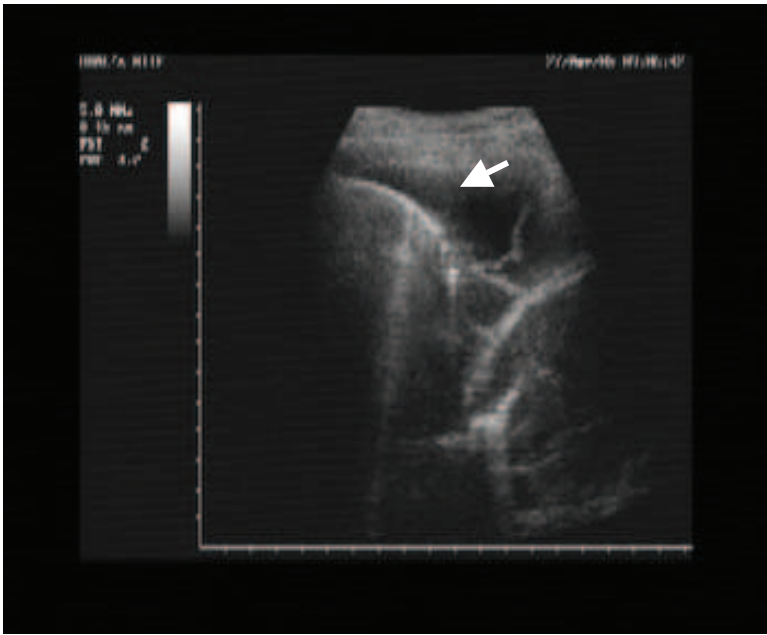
Ultrasonographic picture. Fibrinous masses and “vacuoli” (arrow).
